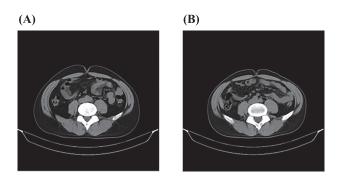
Computed tomography scans of the coronal abdomen (navel; same anatomical position) of one participant analyzed before (A) and after (B) D-BHB intervention. Visceral fat area was reduced following daily consumption of 2.9 g of D-BHB with no changes in diet and no exercise. An example of this participant's visceral fat loss by 25.4 cm<sup>2</sup> in 12 wk is shown. D-BHB, D- $\beta$ -hydroxybutyric acid.
